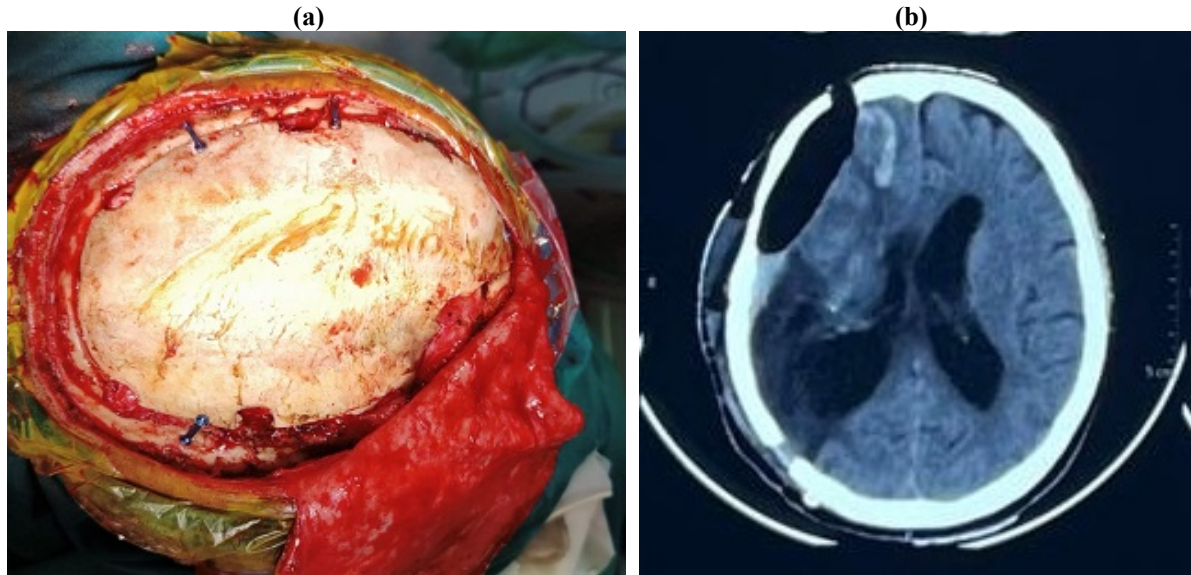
Autologous Bone cranioplasty (AB) (a): intraoperative image, (b): CT image
